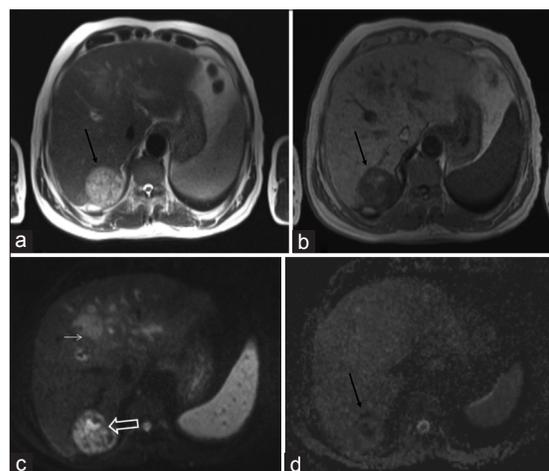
Magnetic resonance imaging of the same patient as Figure 1. The lesion is hyperintense on T2-weighted imaging (black arrow, a) and hypointense on T1-weighted imaging (black arrow, b). The lesion is showing diffusion restriction as evident on the diffusion series (open white arrow, c) and apparent diffusion coefficient mapping images (black arrow, d) and mean apparent diffusion coefficient value is $0.53 \times 10^{-3} \text{ mm}^2/\text{s}$. Diagnosis is confirmed as hepatocellular carcinoma by biopsy. There was mild patchy altered signal intensity in the parenchyma – likely due to portal vein thrombosis (small white arrow, c)
